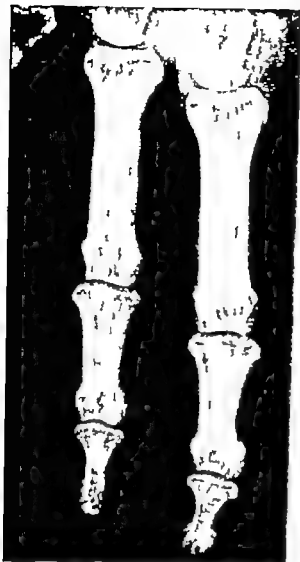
Case 1. The X-ray shows many punched-out lesions, presumably xanthomas of the bone. An X-ray control 2 months after serum bilirubin had become normal, and when serum cholesterol was only slightly elevated, showed that the bone lesions had almost, but not quite, disappeared.
